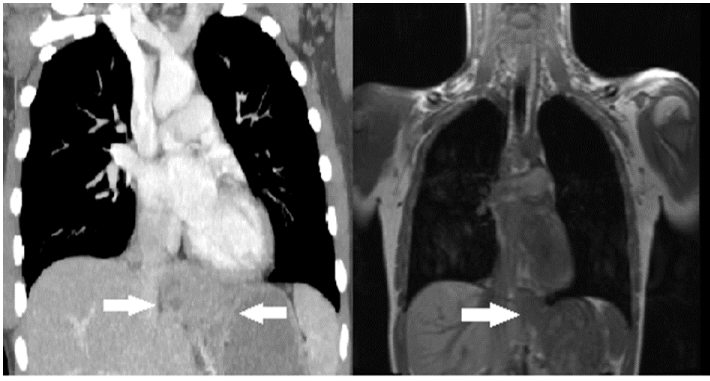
Contrast enhanced computed tomography (CT) scan demonstrating a 45mm peri-oesophageal anterior mediastinal mass with displacement of the left diaphragmatic crus (white arrows).
